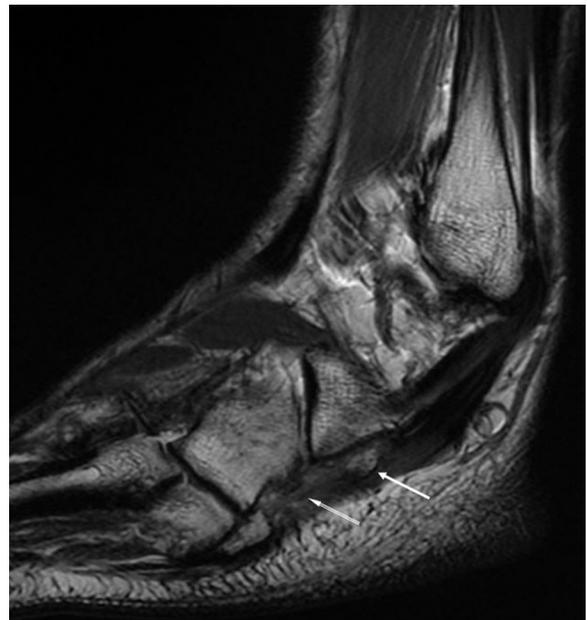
Magnetic resonance image showing the os peroneum (solid white arrow) and a tear in the substance of the peroneal longus tendon (double lined arrow).
